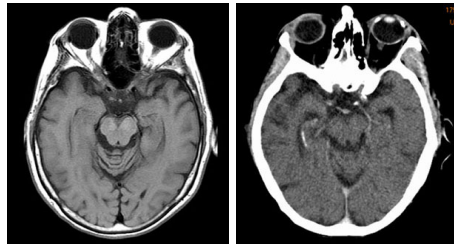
Comparison between MRI(left) and CT(right) images of the brain. Gray and white matter are clearly distinguishable in the MRI image, but not in the CT image, while bone is easy to detect in the CT image.
